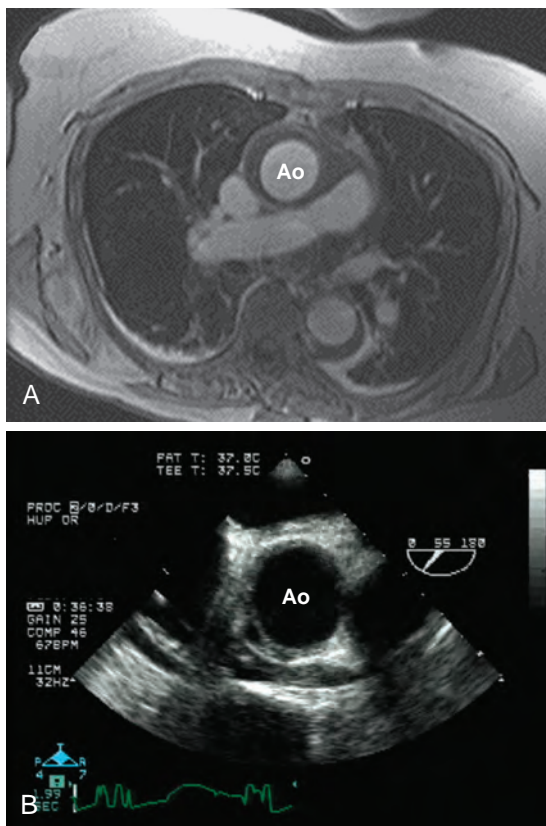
Computed tomographic angiogram of the chest (A) and transesophageal echocardiographic upper esophageal short-axis images of the aorta (B) demonstrating an aortic intramural hematoma that extended from the ascending aorta into the descending thoracic aorta. A crescent-shaped or circumferential thickening of the aortic wall is diagnostic for aortic intramural hematoma. Ao, Aorta.
